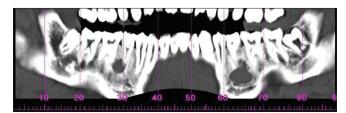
Spiral computed tomography scan (reformatted panoramic view)
